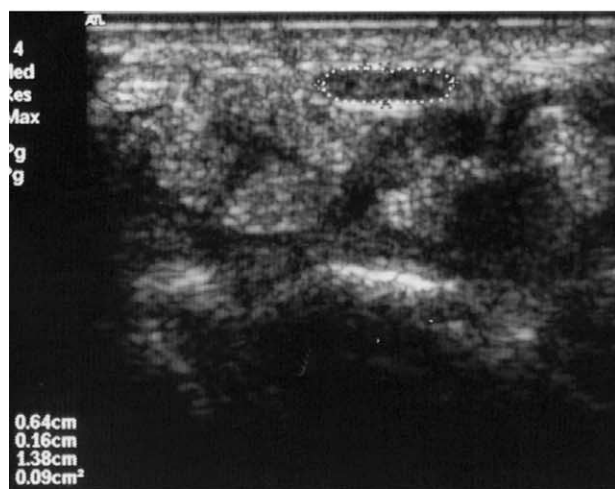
Transverse sonogram of median nerve. (a) An echogenic rim indicating the perineurium (arrowheads) is not always present and its outer margin is difficult to define. (b) Continuous boundary trace (dotted) was used to calculate the area of median nerve just within the perineurium.
